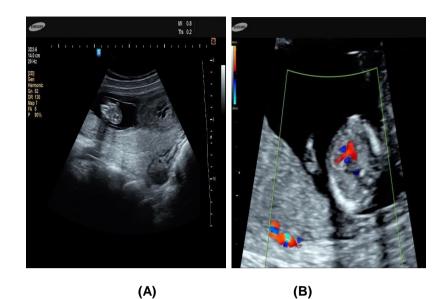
Normal fetal echo, Four-chamber view in anormal fetus at 12w5d shows all chambers and valves, inter atrial septum is seen in this view, Interventricular septum is also seen in this view that is acquired perpendicular to ultrasound beam .(in grayscale (A) and colour Doppler (B)
